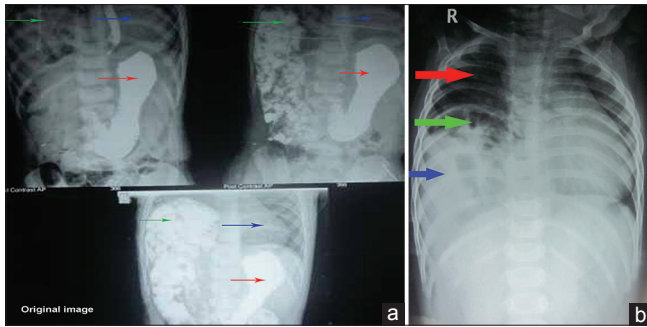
(a) Barium upper gastrointestinal tract radiography (1) Stomach at normal intra-abdominal position (red thin arrow), (2) Few segments of small bowel loops are seen in the right hemithorax (green thin arrow), (3) Cardiac shadow (blue thin arrow). (b) Chest X-ray shows: (1) Well aerated right lung (red thick arrow), (2) There is evidence of bowel loops in the right hemithorax (green thick arrow), (3) Homogenous opacities are also noted in the right lower thorax (blue thick arrow), (4) No demonstrable air containing loops noted in the visualised part of the abdomen
